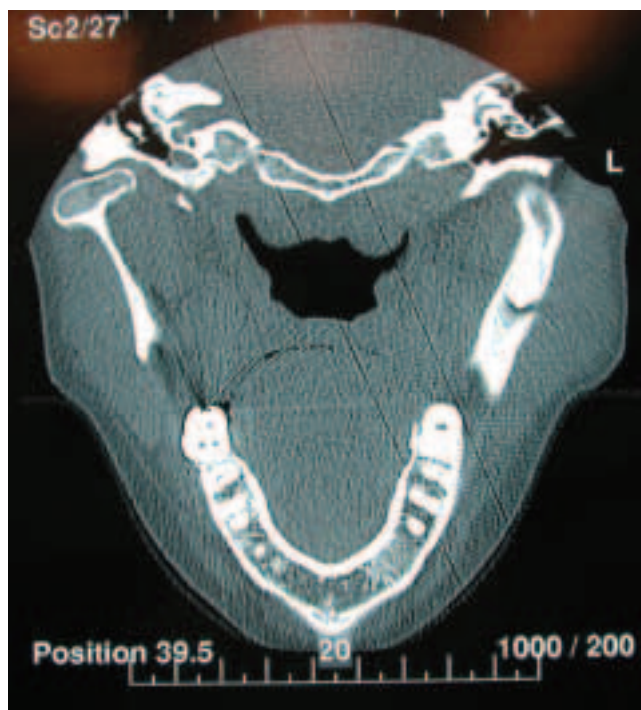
CT-scan section showing the position of the tooth and the buccal perforation
